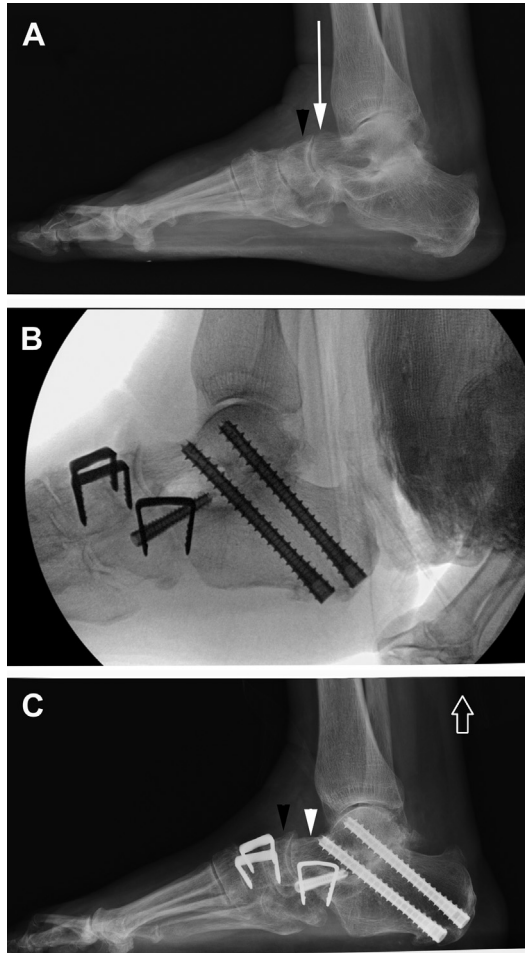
Lateral radiograph (A) showing subtalar, CC, and NC arthritis with mild collapse of the medial column at the NC joint. Note the position of the talus (*white arrow*) relative to the navicular (*black arrowhead*) with no evidence of peritalar subluxation. Intraoperative fluoroscopy (B) of a combined subtalar, CC, and NC fusion was thought to achieve appropriate correction without resultant deformity or collapse of the TN joint. Note the change at 1 year in the position of the TN joint (C) with a clear alteration of the relationship of the navicular (*black arrowhead*) relative to the now more plantar talus (*white arrowhead*). The rigidity that was created within the NC joint was compensated by reciprocal instability of the TN joint in the postoperative period.
